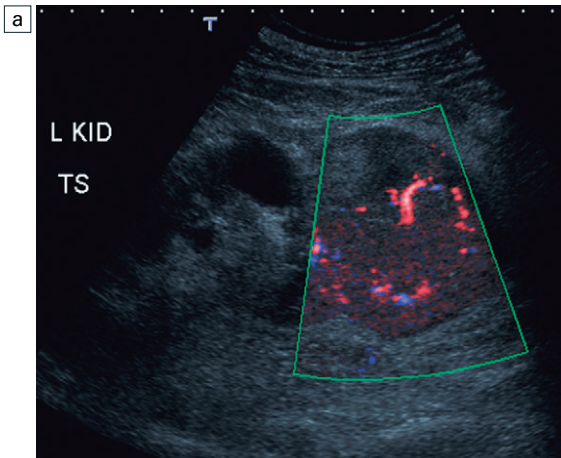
(a) Colour flow Doppler of a lower pole renal mass demonstrating irregular vessels and colour pooling. (b) Colour power Doppler of renal tumour with irregular peripheral flow and central necrosis. (c) Colour flow Doppler of tumour with relatively avascular appearance and only peripheral flow.
